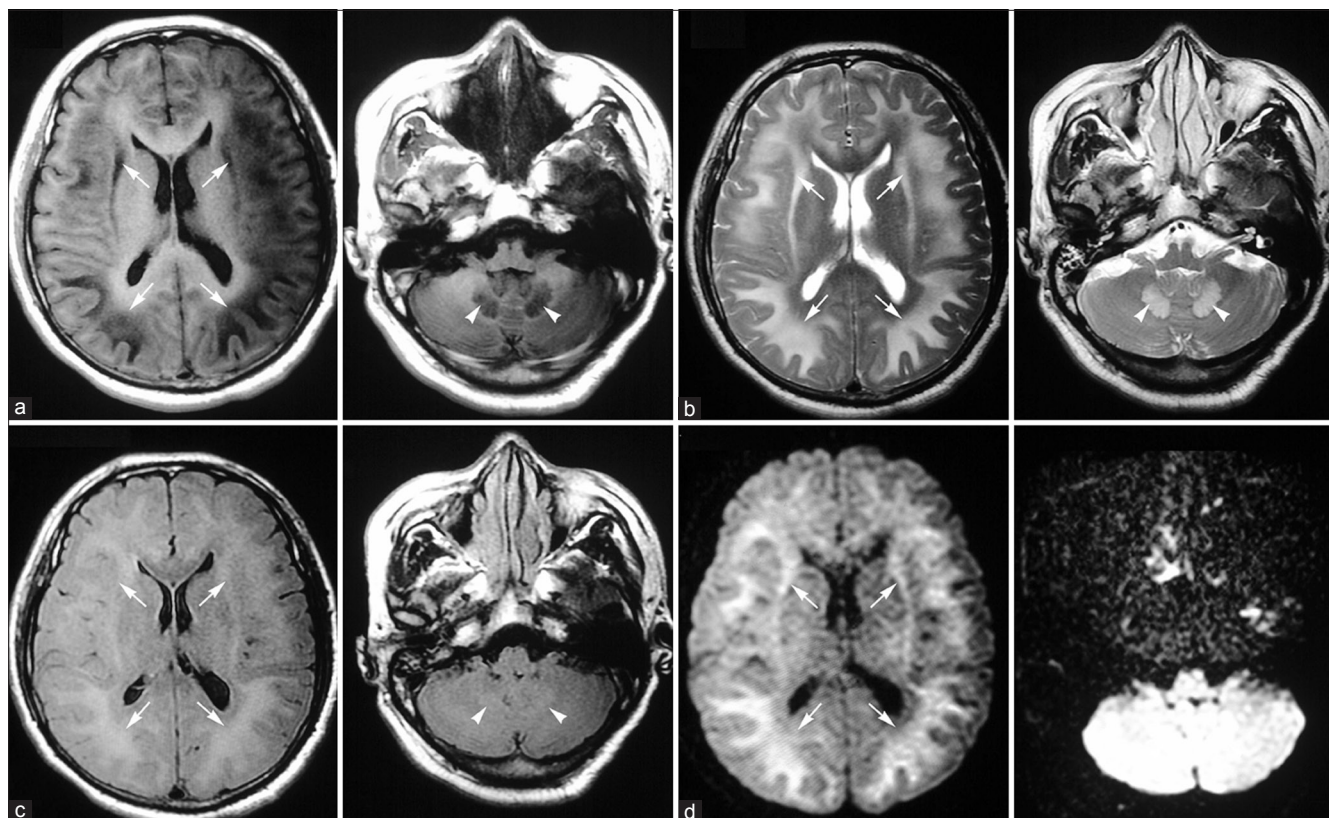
Magnetic resonance imaging shows symmetrical periventricular white matter hyperintensity (arrows) in axial T2-weighted (b), fluid-attenuated inversion recovery (c), and diffusion-weighted imaging (d) images, along with corresponding changes in T1-weighted images (a). The characteristic “sunflower-like” change is readily apparent, particularly in the T2-weighted image. Increased signal is also visible in the cerebellar dentate nuclei (arrowheads). Gray matter-white matter differentiation is preserved
